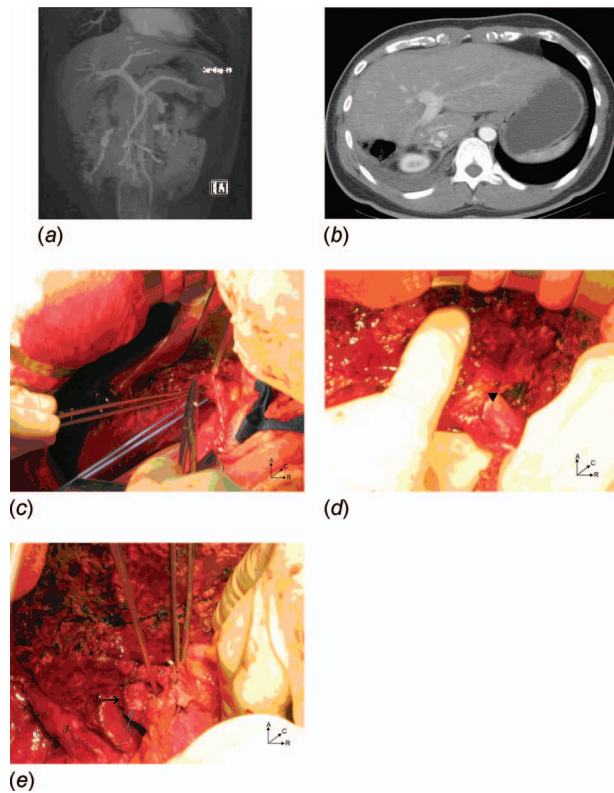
Medical images versus real-life liver and portal vein. (a) A typical MRI angiography image of portal vein. (b) A cross-sectional view of the CT image. (c) Intraoperative view of the liver and the right branch of the portal vein (looped by a blue tape) before the liver resection. (d) The liver was split into the right half and the left half with the right portal vein connected in hand (▼). (e) The right lobe and right portal vein were removed and the cutting surface of the junction of the portal vein was sutured with stitches (→). Note also that the cutting surface of the left lobe liver was shown (A: anterior, C: cephalic, and R: right).
